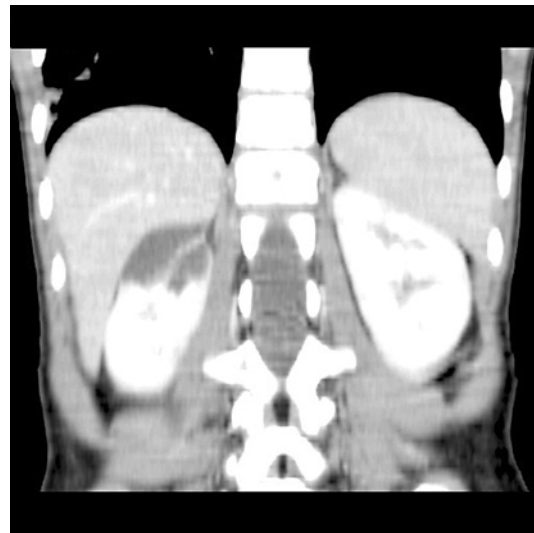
Abdominal CT (coronal images) with a large cystic mass of the upper part of the right kidney.
